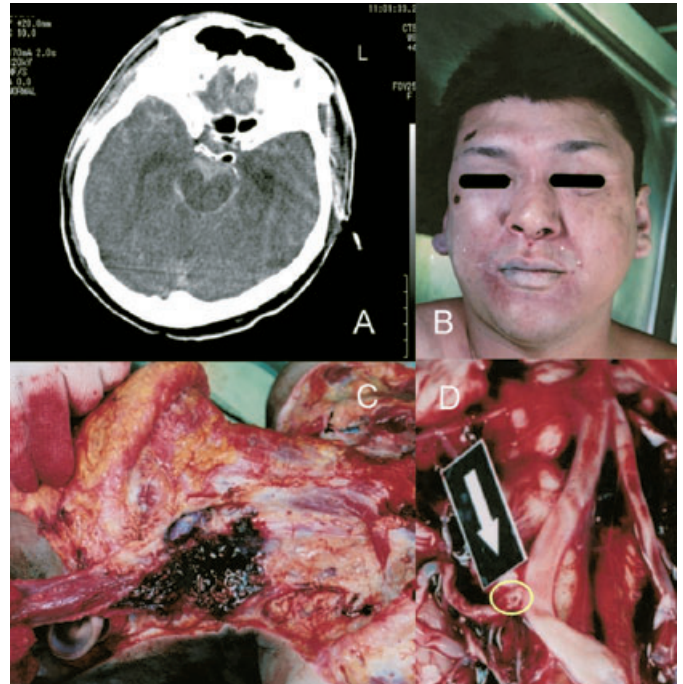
A case of traumatic subarachnoid hemorrhage nearly misdiagnosed as death by disease. A 32-year-old man in cardiopulmonary arrest was taken to the hospital by ambulance. Based on the head computed tomography images scanned at the hospital, the doctor diagnosed a subarachnoid hemorrhage caused by ruptured aneurysms at the base of the brain. However, the doctor reported the case to the police because the situation prior to death was unknown. Police investigation revealed that the man suddenly became unconscious after receiving several blows to the face. A forensic autopsy was then ordered. The autopsy showed an abrasion on the face (B), bleeding in the muscles of the right lateral neck region (C), and damage to the right posterior inferior cerebellar artery (arrow D). The cause of death was then determined to be traumatic subarachnoid hemorrhage caused by blows to the head and neck area.
